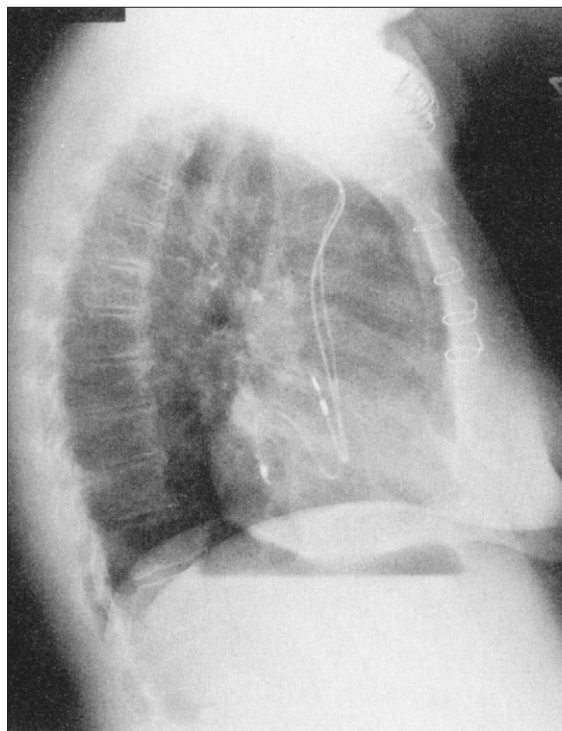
Lateral chest radiograph of lead passing through atrial septum
